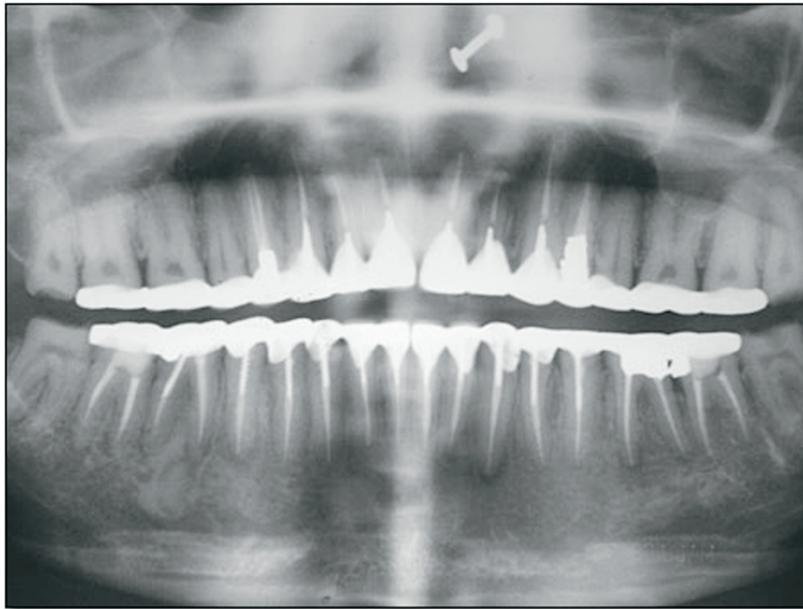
A post-operative panoramic radiograph of the patient's dentition one year after treatment.
